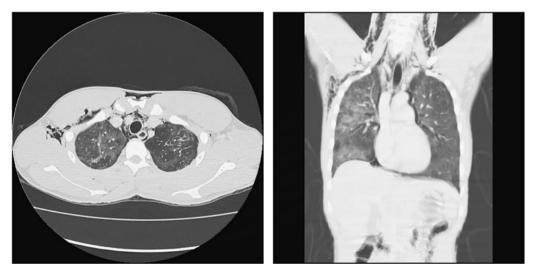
Computed tomography of the patient. Ground-glass appearance of infiltration was noted on bilateral lung fields with prominent free air at the mediastinum and beneath the skin at the neck and thoracic cage area.
